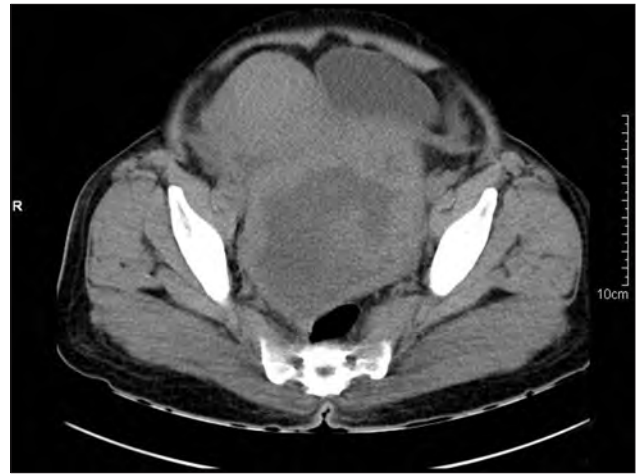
Plain CT axial image showing mixed density lesion in the pelvis displacing the uterus and bladder anteriorly and rectum posteriorly, suggesting ovarian origin
